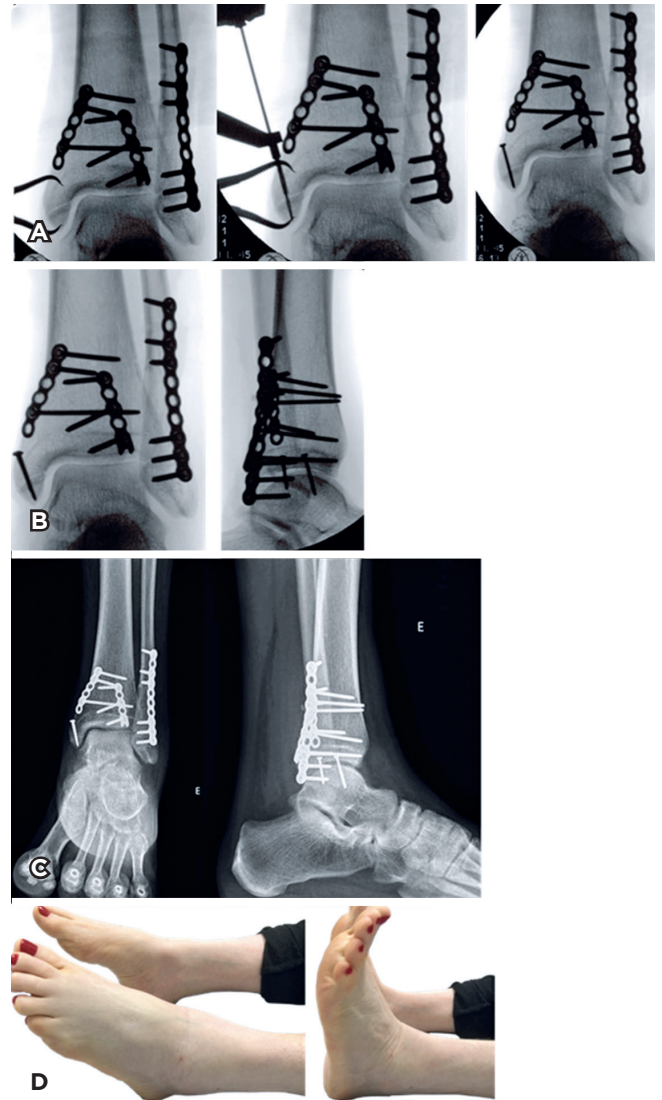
(A) Intraoperative fluoroscopic images showing fracture reduction and antegrade fixation of the medial malleolus using minifragment lag screws (2.4- and 2.0 mm screws). Observe the reverse obliquity of the medial malleolar fracture. (B) Postoperative fluoroscopy images in anteroposterior and lateral views showing fracture fixation using minifragment implants. (C) Postoperative radiographs after six weeks showing complete fracture healing. (D) Observe the symmetric range of motion of both ankles after 12 weeks postoperatively.
